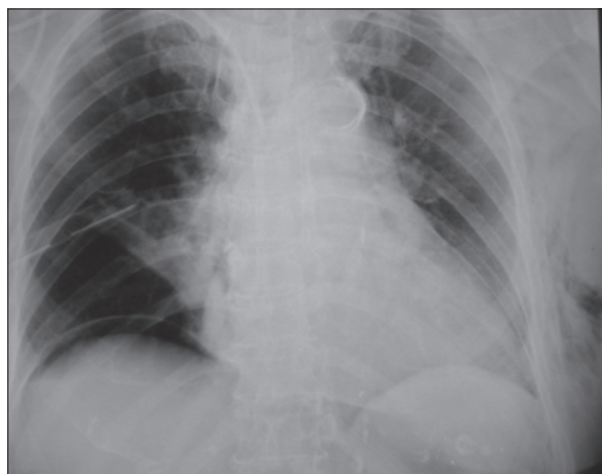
Gas under the diaphragm and pneumothorax identified by chest X-ray following colonoscopy-related perforation
